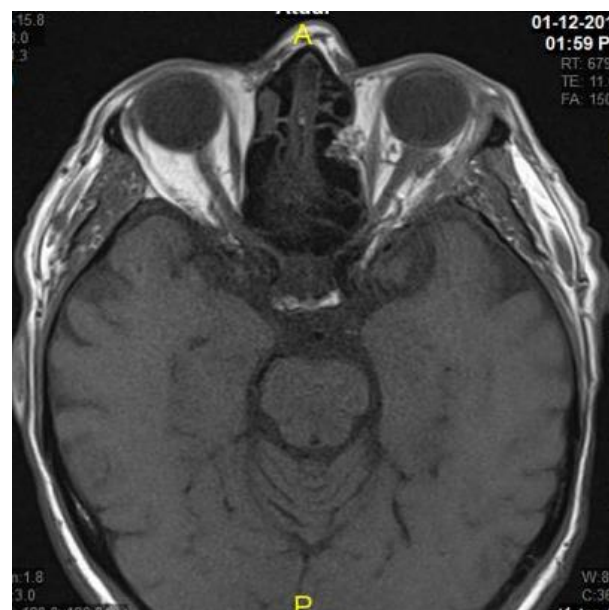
Magnetic resonance imaging in P.O. of 45 days, showing improvement of proptosis of the eyeball.
